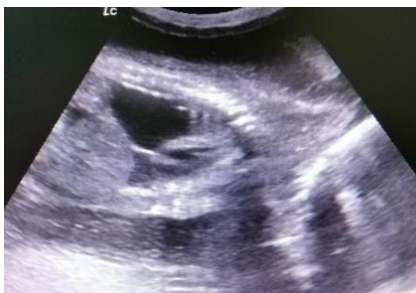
Obstetrical ultrasonography indicates fetal bilateral pleural effusion, left more than right side, where left massive pleural effusion pushing left lobe of lung and the heart to the right thoracic cavity, no pericardial effusion, both lungs hypoplasia at 24 weeks POA
